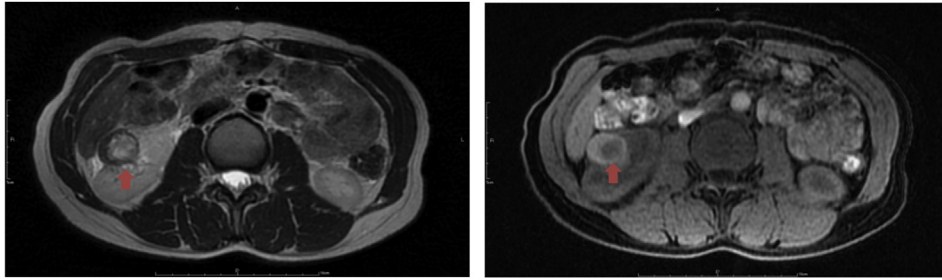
Magnetic resonance imaging of the abdomen showing a right renal tumor measuring approximately 3.4 cm × 3.7 cm (arrow).
